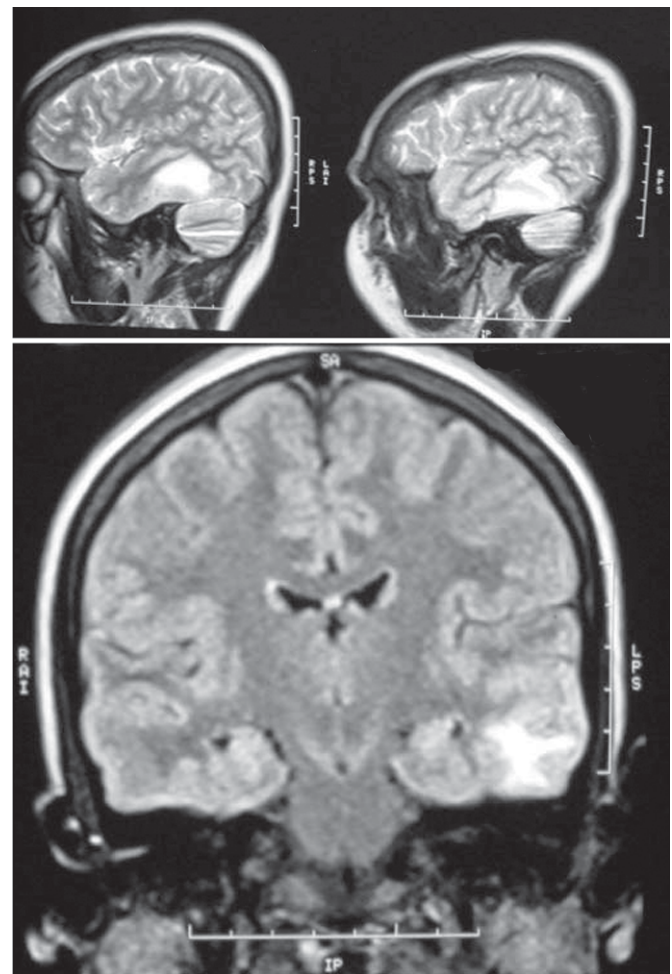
T₂-weighted MRI showing a hyperdense lesion (venous infarct) in the left temporal lobe
